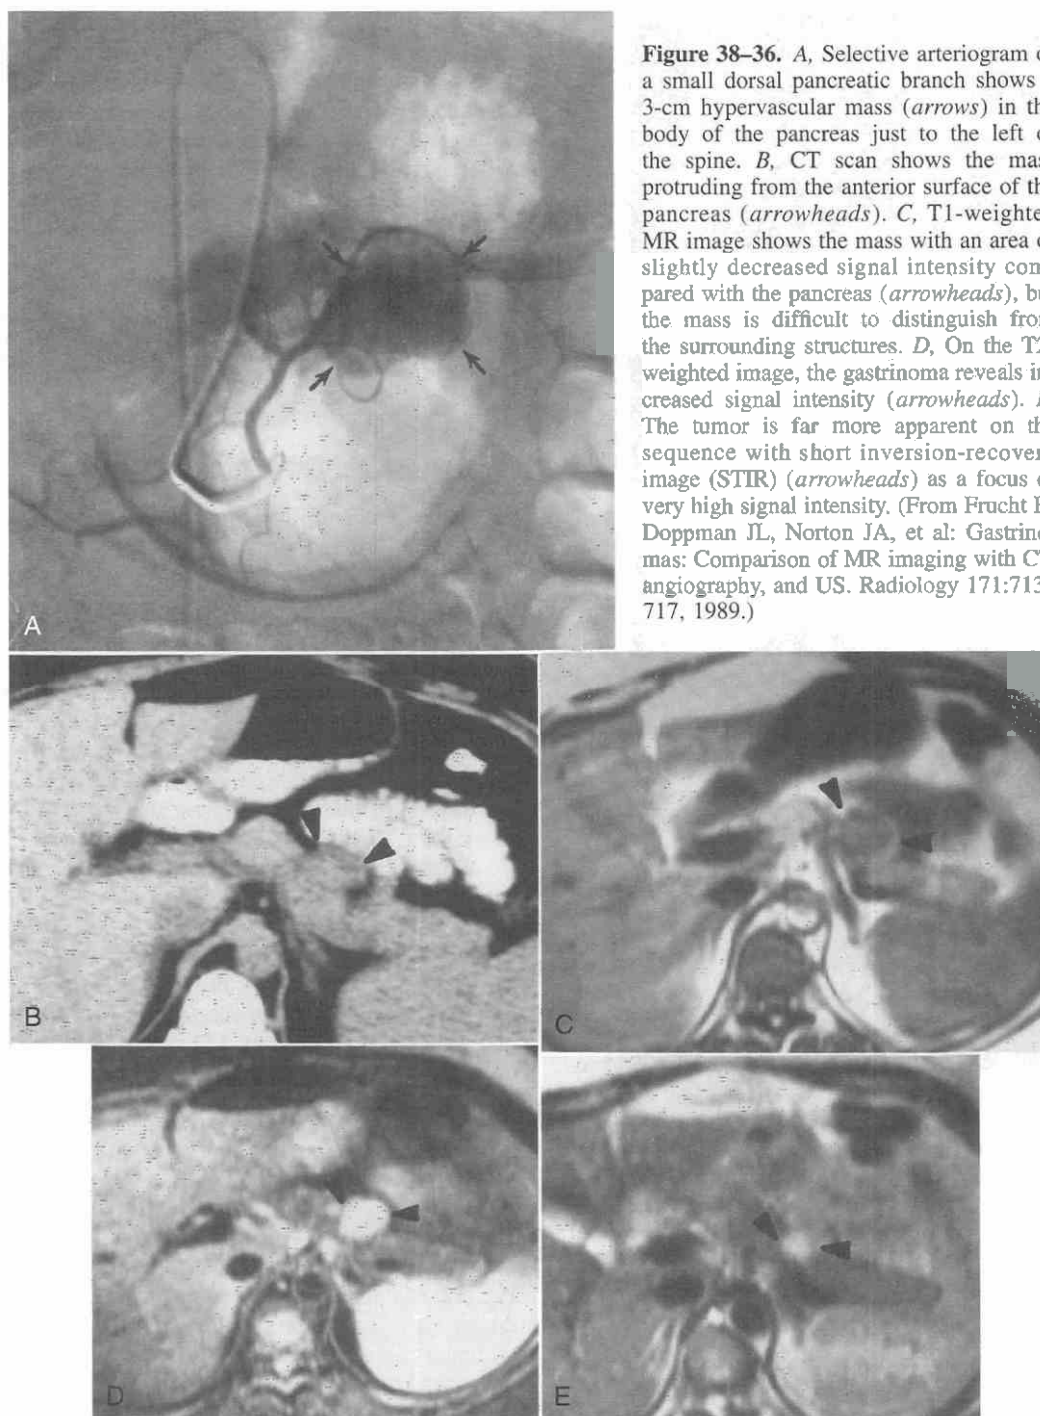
A, Selective arteriogram of a small dorsal pancreatic branch shows a 3-cm hypervascular mass (arrows) in the body of the pancreas just to the left of the spine. B, CT scan shows the mass protruding from the anterior surface of the pancreas (arrowheads). C, T1-weighted MR image shows the mass with an area of slightly decreased signal intensity compared with the pancreas (arrowheads), but the mass is difficult to distinguish from the surrounding structures. D, On the T2-weighted image, the gastrinoma reveals increased signal intensity (arrowheads). E, The tumor is far more apparent on the sequence with short inversion-recovery image (STIR) (arrowheads) as a focus of very high signal intensity. (From Frucht H, Doppman JL, Norton JA, et al: Gastrinomas: Comparison of MR imaging with CT, angiography, and US. *Radiology* 171:713-717, 1989.)
